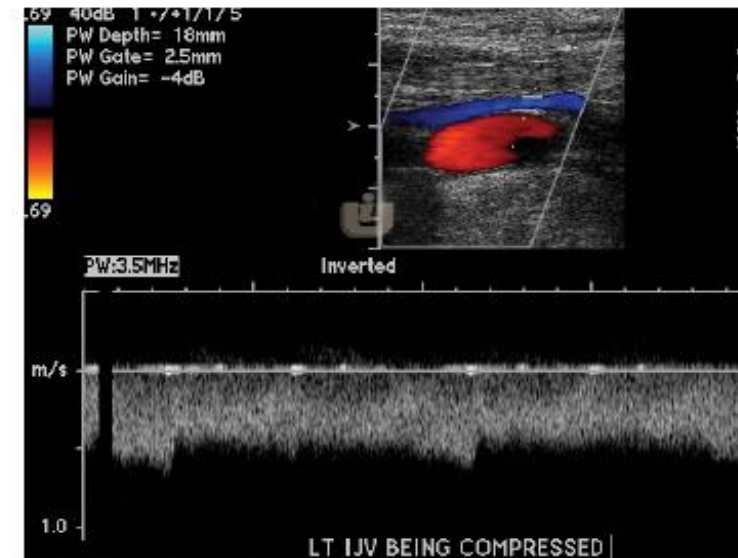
Venous compression confirmed by spectral Doppler (continuous flow/lacks pulsatility)
